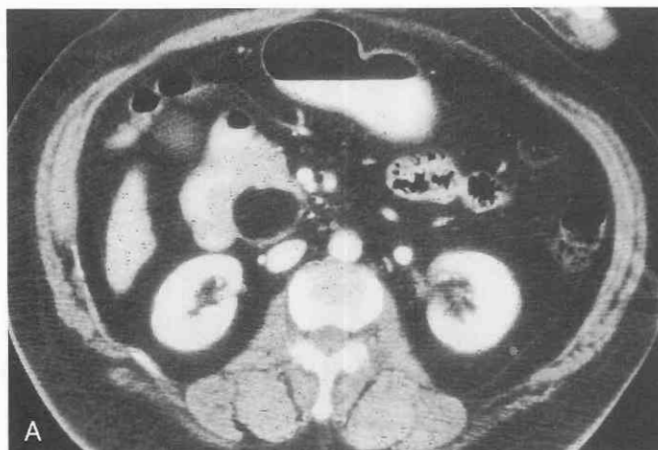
A, CT scan in a 45-year-old man after a motor vehicle collision. The patient sustained multiple pelvic fractures and serious cranial injuries. Contrast-enhanced CT scan shows incidental 3 × 4-cm fatty mass in pancreatic head. B, CT scan in a 47-year-old man admitted after several days of nausea, vomiting, and diffuse epigastric pain radiating to the back. The patient had history of multiple hospitalizations for abdominal pain. (This type of appearance has been described as *lipomatous pseudohypertrophy*.) C, CT scan in a 36-year-old woman after resection of liposarcoma that involved the pancreatic body and tail. The patient had undergone wide resection relatively recently, with splenectomy, left nephrectomy, and distal pancreatectomy. Contrast-enhanced CT scan shows large, recurrent liposarcoma adjacent to residual pancreas. Note the foci of fat in the mass. At surgery, the mass was adherent to residual, density and intermediate density, represents liposarcoma. (From Katz et al., AJR, Feb. 1999.)
